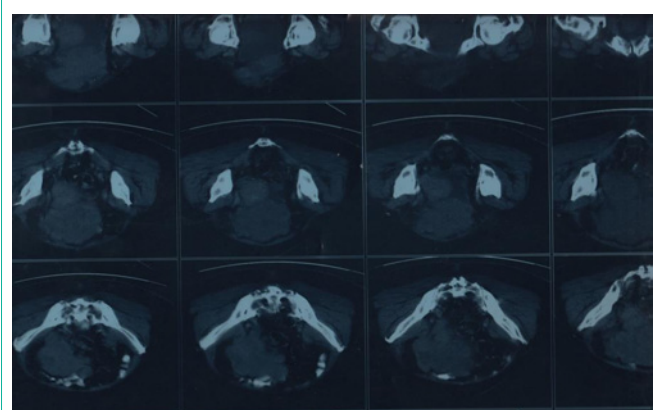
Abdominal CT scan showing a large multi lobulated heterogeneous mass lesion in the pelvis.
